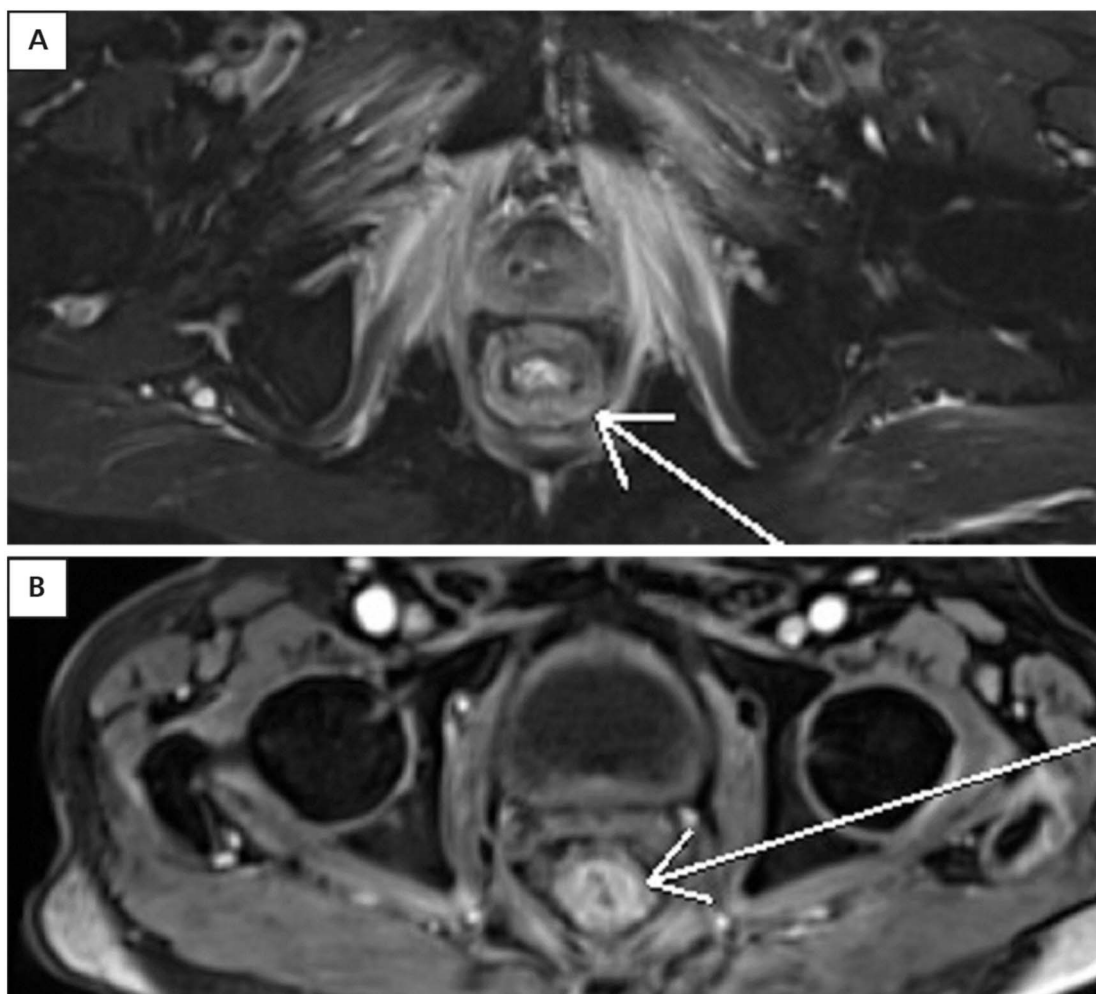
Transverse T2-weighted fat-suppressed image (A) shows the increased signal intensity within the muscles of the pelvic floor representing typical features of edema after radiation therapy. Note rectal wall thickening with submucosal high signal intensity (arrow) also consistent with edema. The presence of submucosal edema and intense postgadolinium enhancement (arrow) depicted in T1-weighted fat-saturated image (B) is consistent with inflammation
